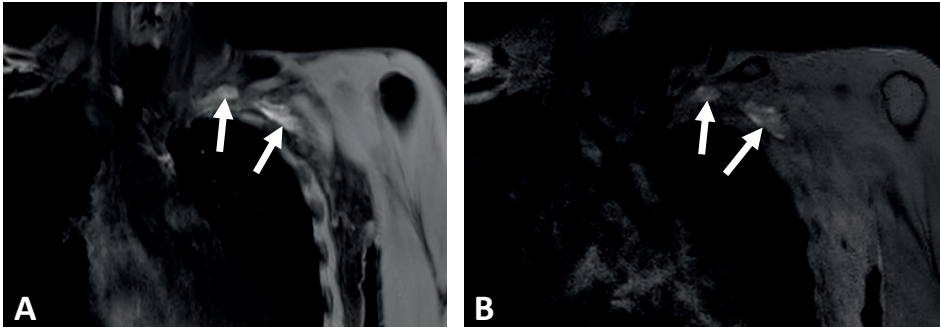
2B – Unenhanced MRI sequences: MRDTI (A) and 3D TSE-SPAIR (B) acquisitions of the upper extremities, coronal view.
